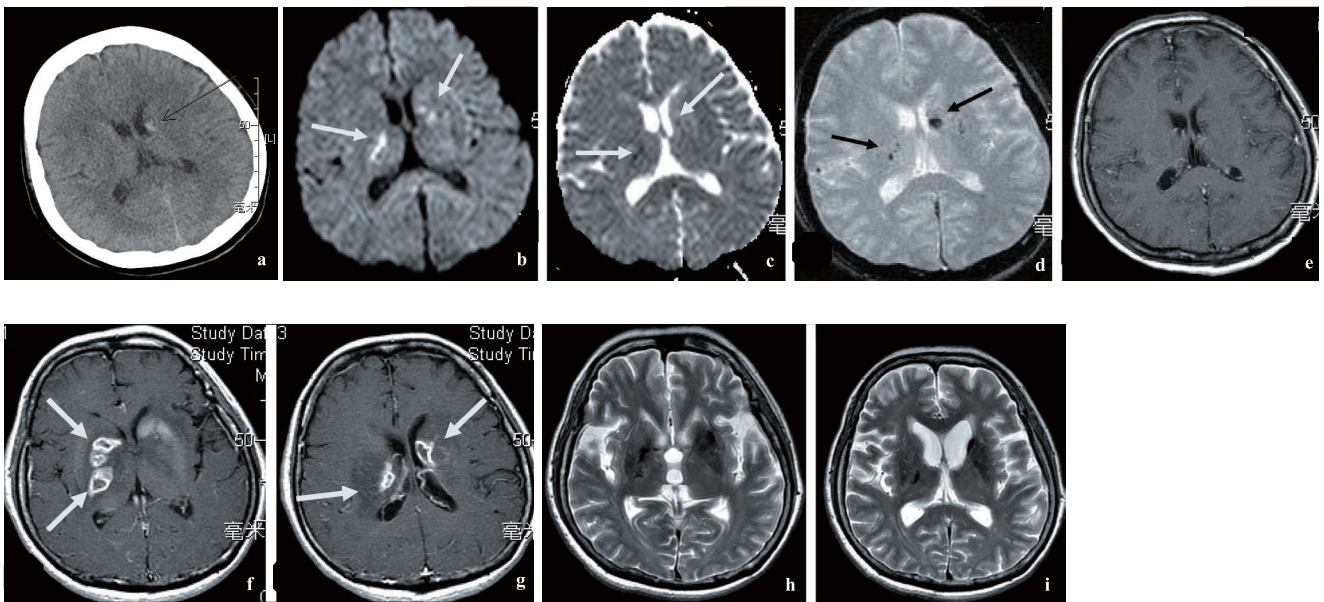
A series of neuroimages of a 57-year-old woman with culture proven *Klebsiella pneumoniae* meningitis⁽¹²⁾. The patient presented to the emergency department on June 3, 2008 with the chief complaint of fever, progressive left limb weakness and altered consciousness for 2 days. Initial cranial computed tomography (CT) (Figure 1a) revealed a small hemorrhage located at the left caudate nucleus (arrow). Brain magnetic resonance (MR) imaging study of the same day revealed infarction with hemorrhagic change over the left caudate nucleus and right basal ganglia area (Figure 1b: Diffusion-weighted image shows hyperintensities at the right internal capsule (arrow) and left caudate nucleus (arrow). Figure 1c: Apparent diffusion coefficient map shows hypointensities at the right internal capsule (arrow) and left caudate nucleus (arrow), Figure 1d: Gradient echo sequence reveals decreased signals at left caudate nucleus and right internal capsule (arrow), Figure 1e: Negative finding in gadolinium contrast-enhanced T1-weighted image). Subsequent brain MR imaging follow-up study (June 23, 2008) revealed multiple brain lesions including abscess formation (Figures 1f and 1g: Gadolinium contrast-enhanced T1-weighted images shows multiple lesions with rimmed-enhancement at the areas of bilateral basal ganglia (arrow)). MR imaging (T2-weighted images) follow-up studies on July 23, 2008 (Figure 1h) and on February 12th, 2009 (Figure 1i) revealed nearly complete remission of brain abscess. In the therapeutic course, liver and pulmonary abscess formations were noted concomitantly by subsequent CT and sonographic studies. Concurrent urinary tract infection and herpes zoster were also noted during the clinical course.
